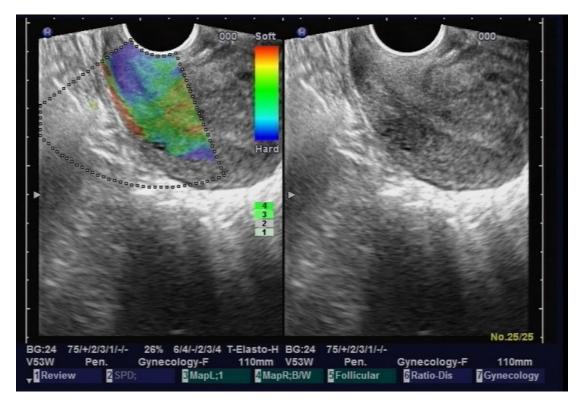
Cervical elastic ultrasound.
